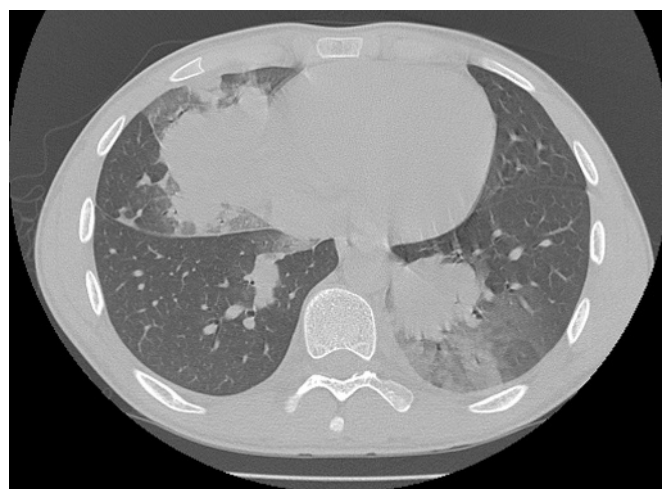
Axial CT image demonstrating air space consolidation of the right middle and lower lobes bilaterally.
